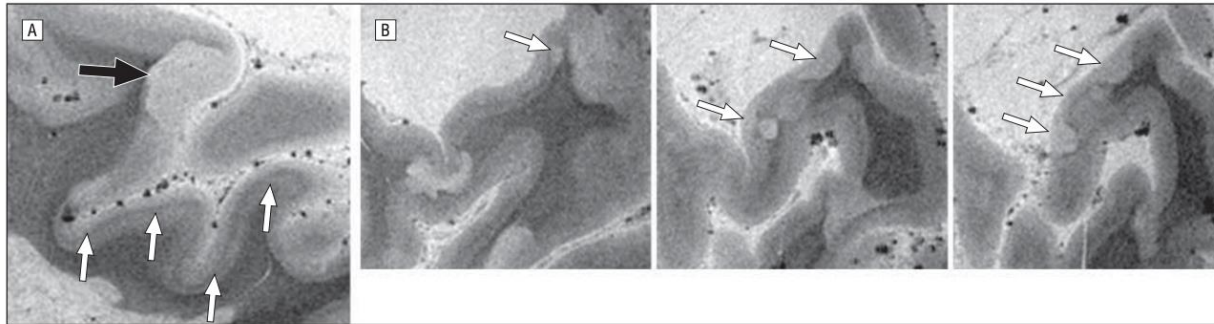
T2*-weighted gradient-echo magnetic resonance images. A, A type 4 cortical lesion (large arrow) and the line of Gennari (small arrows) in the occipital lobe. B, A cortical lesion morphs on consecutive magnetic resonance imaging cuts from a round, small type 2 lesion into a type 4 lesion (extending throughout the cortex) and fuses with a second lesion through a subpial bridge (arrows).
